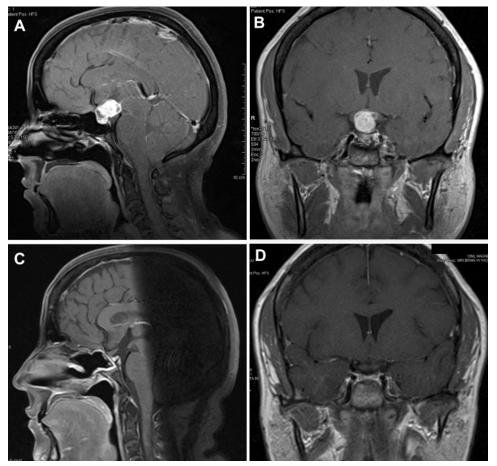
Complete resection by initial postoperative MR imaging is confirmed with intraoperative endoscopic assessment. A and B: Preoperative sagittal and coronal T1-weighted MR images. C and D: Postoperative sagittal and coronal T1-weighted MR images showing complete resection. Intraoperative endoscopic inspection indicated complete resection (see Video 2).
